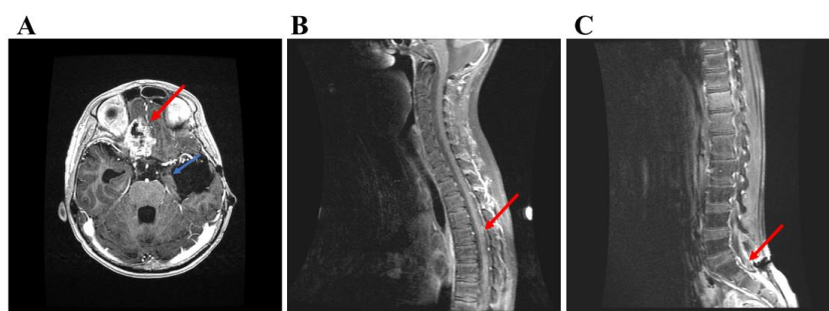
The lasted MRI images scans. A) The brain MRI images displayed the initial site marked by a blue arrow and the new lesion site indicated by a red arrow. B) The MRI images of the spine depicted the presence of T-spine seeding, highlighted by a red arrow. C) The MRI images of the spine showed the presence of L-spine seeding, marked with a red arrow.
